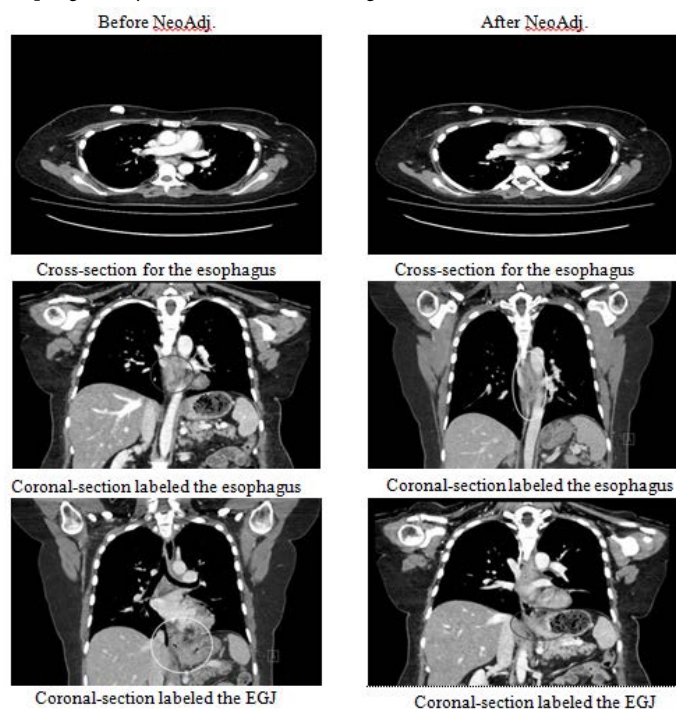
All CT images Obtained from the PAC system of the patient
